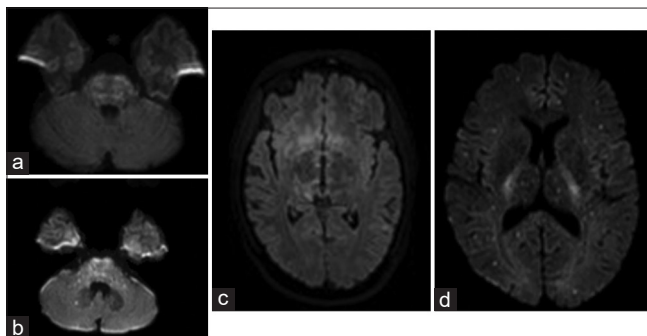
MRI Diffusion weighted image [DWI] sequences. Panel A shows tiny punctate lesions in the pons. Panel B shows pontine lesions extending into the middle cerebellar peduncels and a few lesions in the cerebellum. Panel C shows punctate lesions in the thalamo-hypothalamic area. Panel D shows the 'Starry sky' appearance of multiple cortical and subcortical hyperintensities
